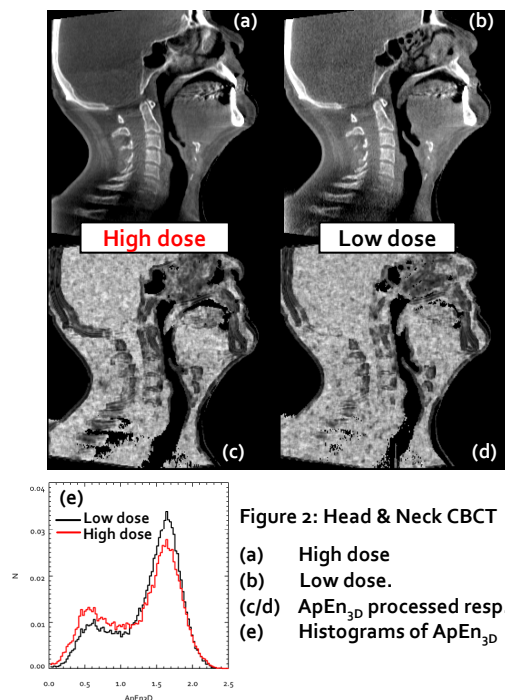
Head & Neck CBCT
